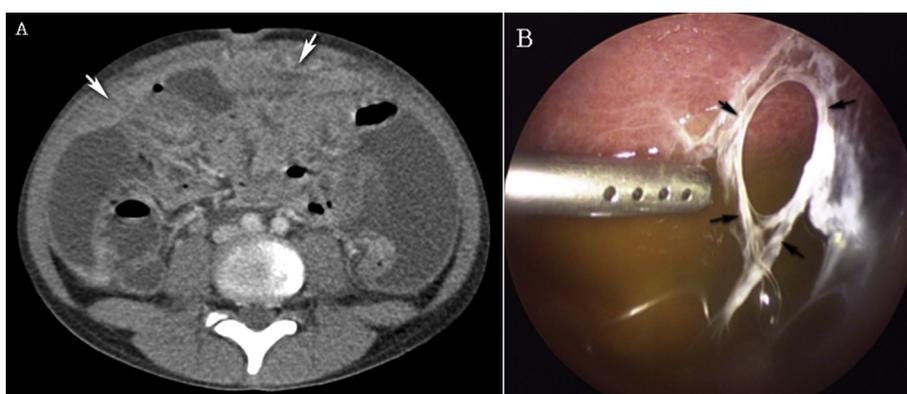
A. Abdominal CT scan with contrast enhanced showed massive ascites with thickening of omentum and peritoneum (white arrow), associated with lymphadenopathy. B. Laparoscopic surgery found thickened peritoneum and omentum coated with fibrinous strands (black arrows).
